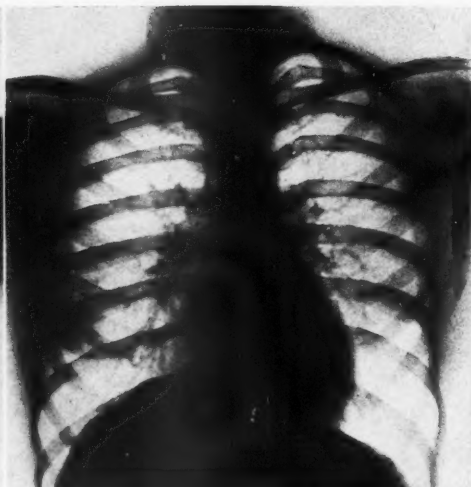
Physical signs positive, x-ray findings negative: bacilli negative. Physical signs: right lung, moderately coarse râles to third rib; left lung, moderately coarse râles to third rib. X-ray findings: negative.
